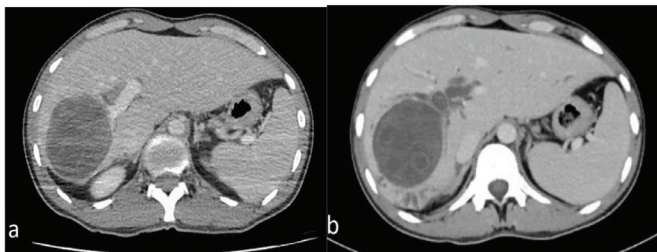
Contrast-enhanced CT image of a 28-year-old male patient admitted to the emergency department with sudden onset abdominal pain two weeks before and at the time of presentation; type 3 cyst hydatid in the liver, before (a) and after rupture (b) into the intrahepatic biliary tract
